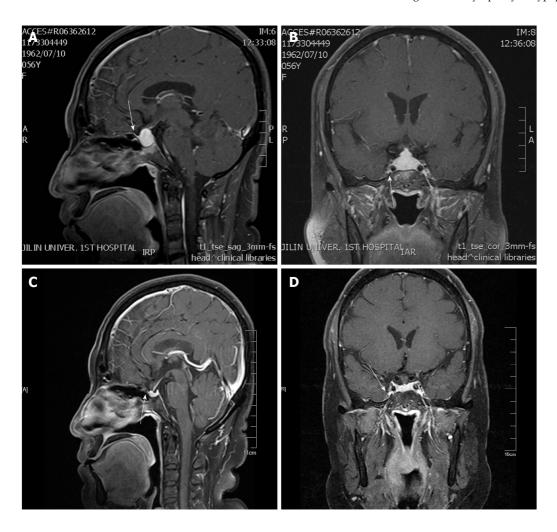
Postgadolinium-enhanced sagittal magnetic resonance imaging. A: Before treatment showing a dural caudal sign (arrow); B: Pretreatment postgadolinium-enhanced coronal magnetic resonance imaging showing no cavernous sinus involvement (arrow); C: Almost disappears after treatment (arrow); D: After treatment postgadolinium-enhanced coronal magnetic resonance imaging showing no cavernous sinus involvement (arrow).
